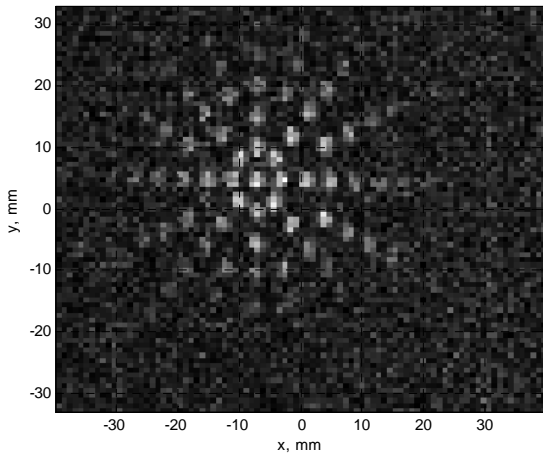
ULF MRI measured for water at 94  $\mu$ T. The imaging parameters are listed in Table 1.
